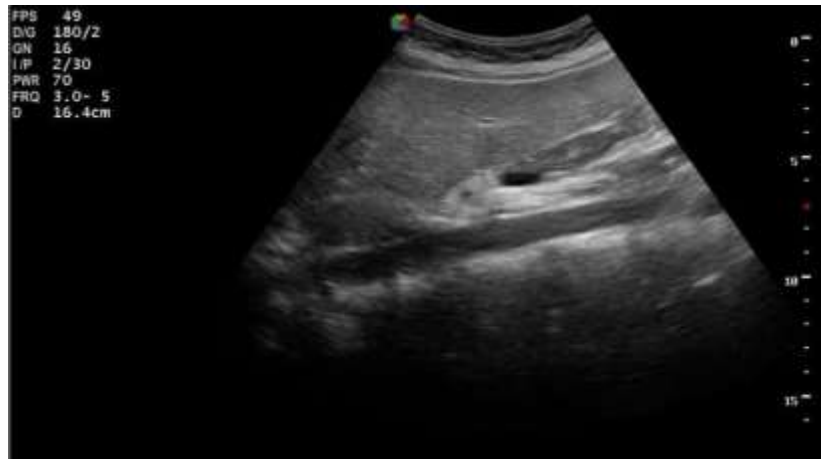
Abdominal ultrasound for fatty liver
